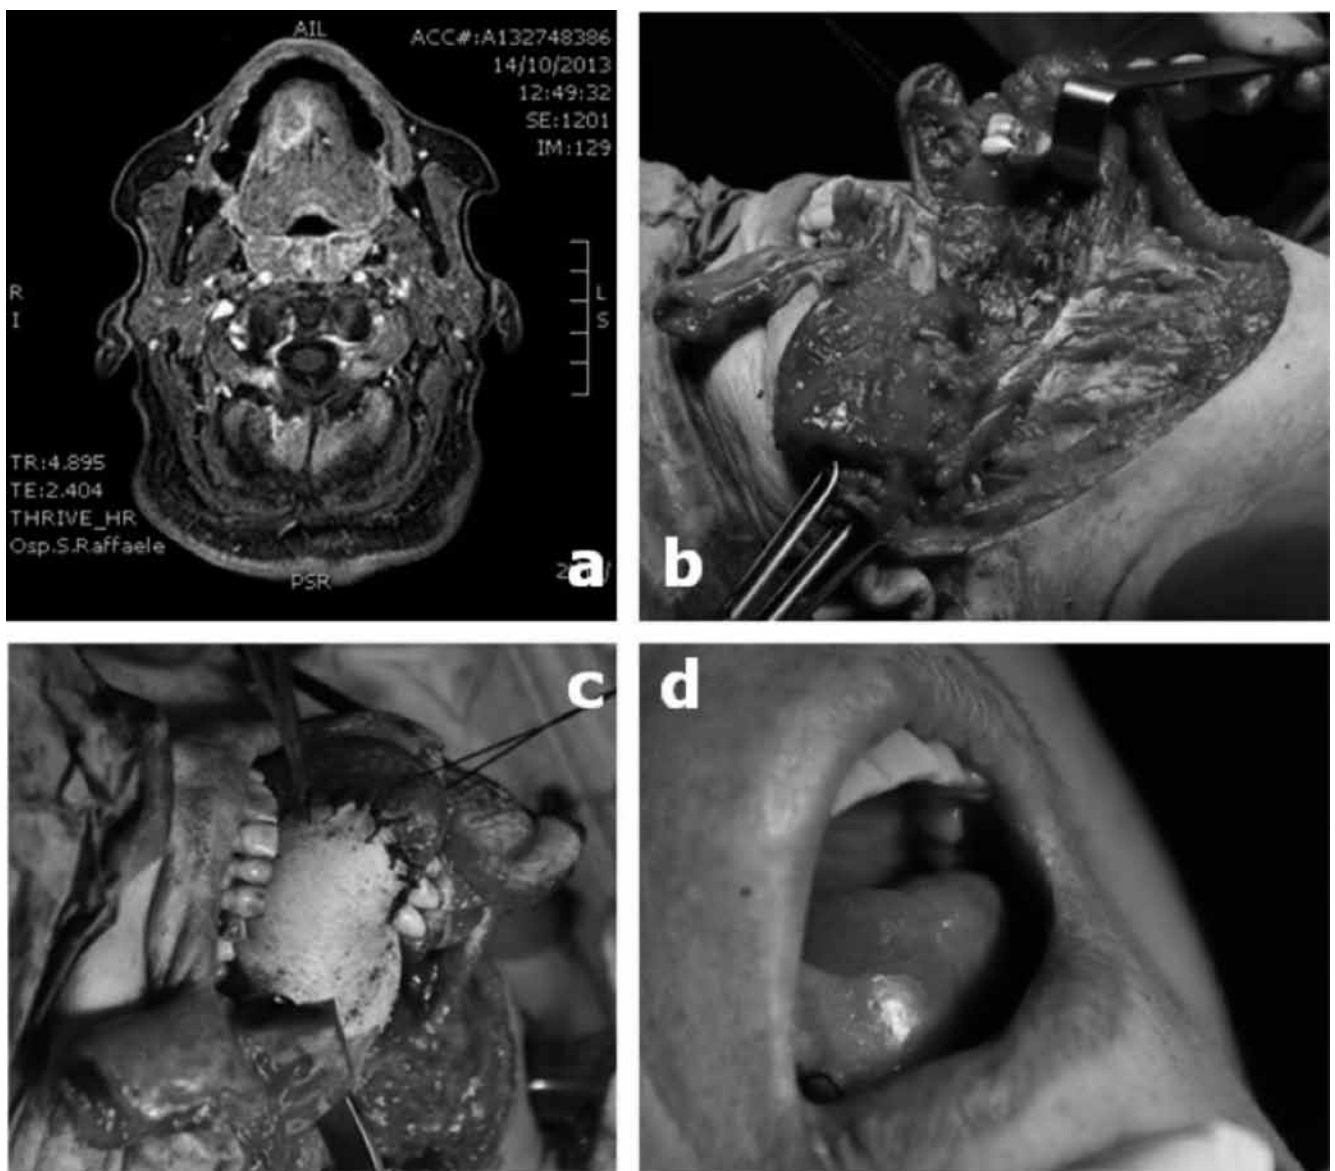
a) MRI imaging showing the tongue lesion; b) right hemiglossectomy through a trans-mandibular approach; c) reconstruction of the tongue with the supraclavicular flap; d) final outcome.
